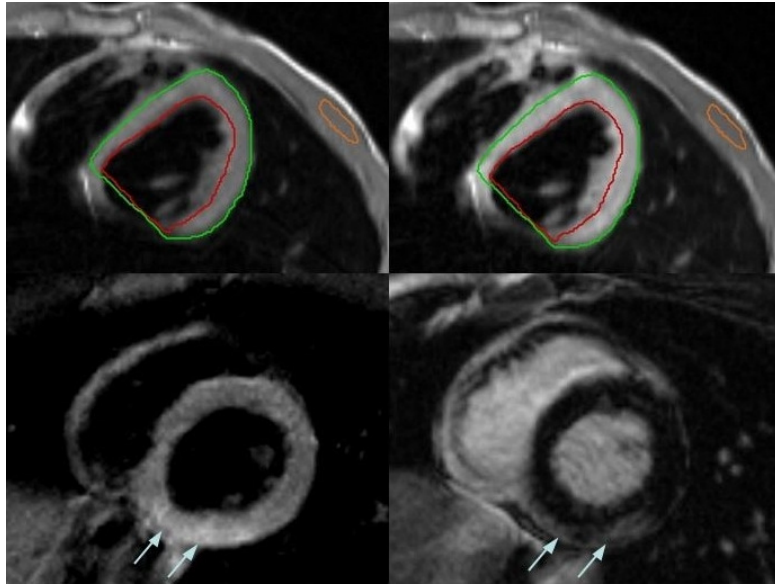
Comprehensive cardiovascular magnetic resonance in a 15 year old male presenting with acute chest pain, elevated troponin, ST-segment elevation and negative coronary angiography. Top: Pre (left) and early post (right) gadolinium-DTPA axial T1-weighted spin echo images of the same slice. The intense myocardial enhancement relative to that of the skeletal muscle is even visually appreciable (exact value = 6.8). The T2-weighted image (bottom, left) shows a posterolateral, predominantly subepicardial focal high T2 signal intensity, which corresponds to a similar subepicardial area of late gadolinium enhancement (arrows, bottom, right) with possible pericardial enhancement as well¹⁵.
